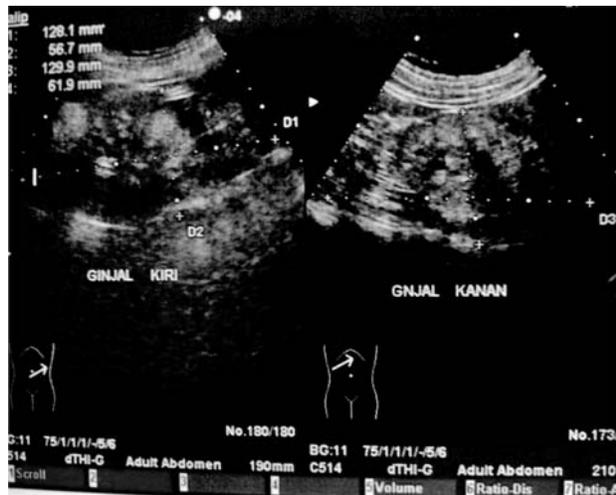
Renal ultrasound in Case 1. Multiple hyper-echoic lesions in both kidneys suggesting AMLs. Left and right kidney sizes were 12 x 5.6 and 12 x 6.2 cm, respectively.
